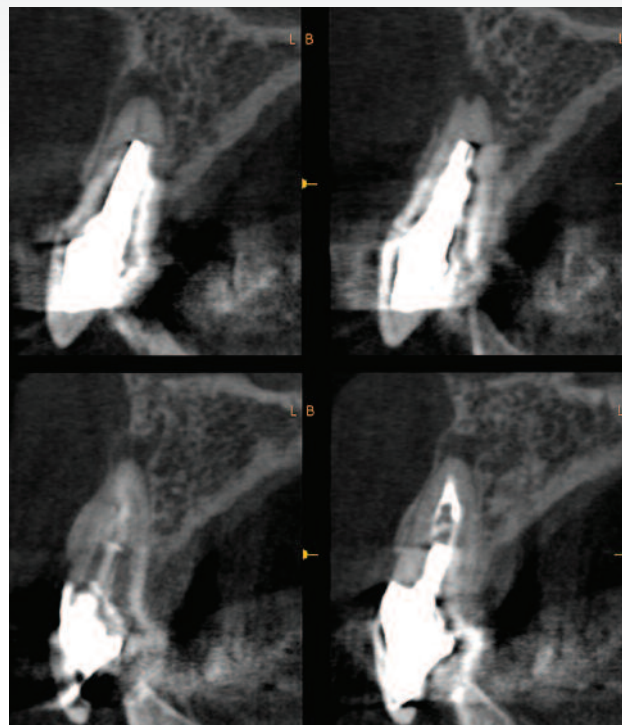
Preoperative CBCT scan for comparison
